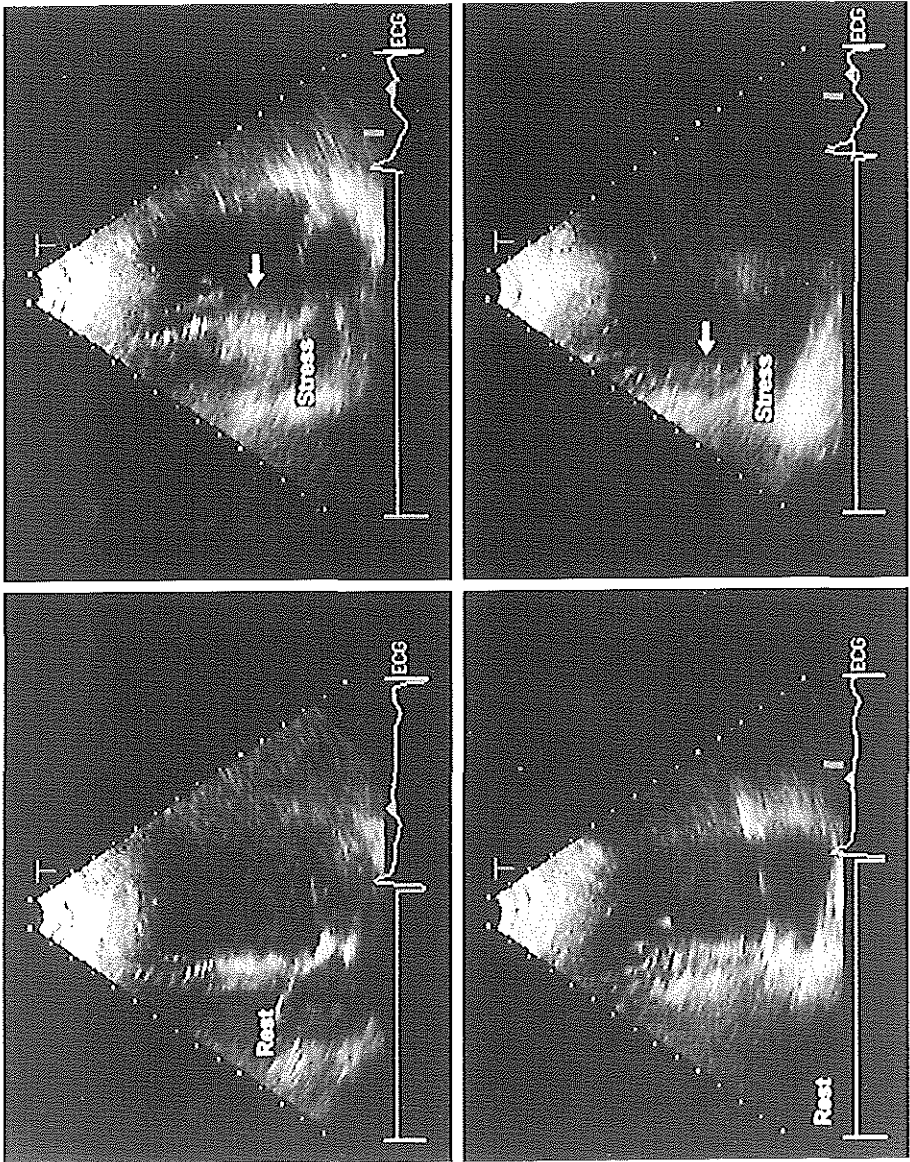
2-dimensional echocardiographic images at rest and at high dose dobutamine stress from the apical 4 chamber view (top) and apical 2 chamber view (bottom), showing dyskinesia of the basal posterior septum and basal inferior wall at high dose dobutamine stress indicated by arrows.
